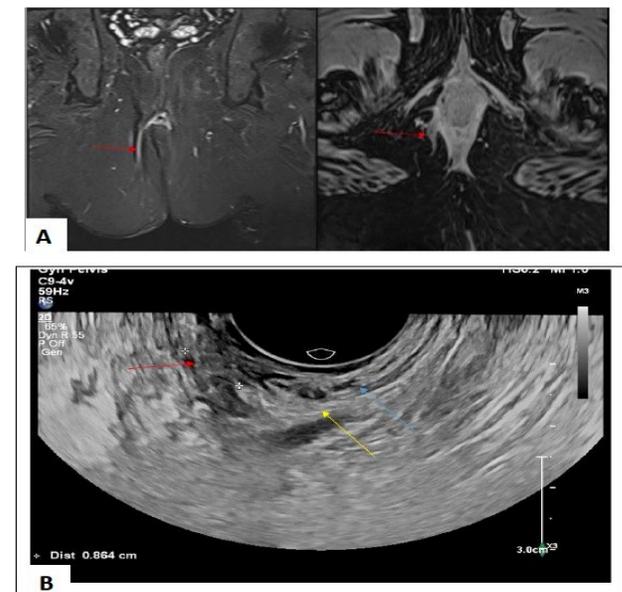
36-year old male present with perianal discharge. A) MRI fat sat T1+C axial and T2 fat sat coronal showing transsphincteric fistula (red arrow); B) endocavity probe US show transsphincteric fistula (red arrow) cross through internal (blue arrow) and external sphincter (yellow arrow).
